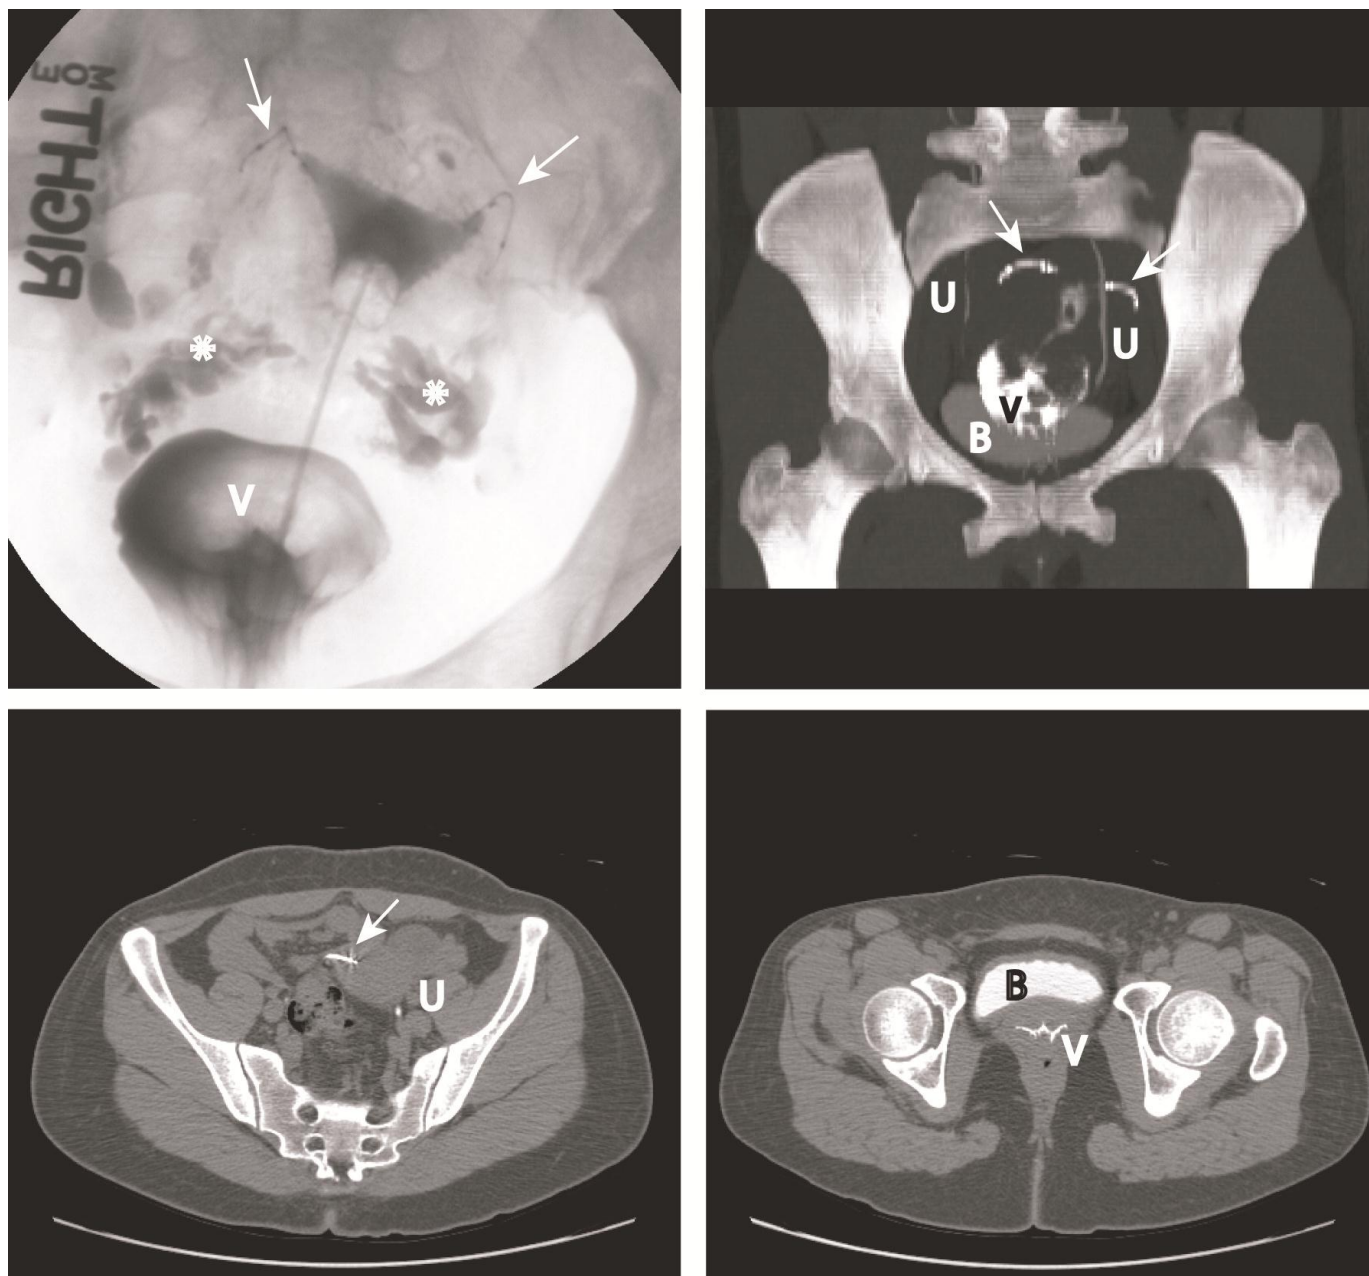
32 year old female with uterine venous intravasation status post Essure hysteroscopic sterilization. 6 month post-procedure HSG (a) again demonstrates Essure inserts (arrows) and extrauterine contrast accumulation (*). There is also contrast within the vaginal vault (V). Non-contrast pelvic CT (GE 4-slice scanner, 2.5mm axial images, 120 kVp, 204mAs) obtained immediately after the HSG (c,d) demonstrates the Essure inserts (arrow) and contrast within the uterus and vaginal vault (V), but no free contrast spillage in the pelvis. Contrast in the ureters (U) and bladder (B) suggest clearance of contrast from the vascular circulation, consistent with venous intravasation. Coronal 5.0cm thickness maximum intensity projection image (MIP) from the same CT (b) demonstrates these same findings.
